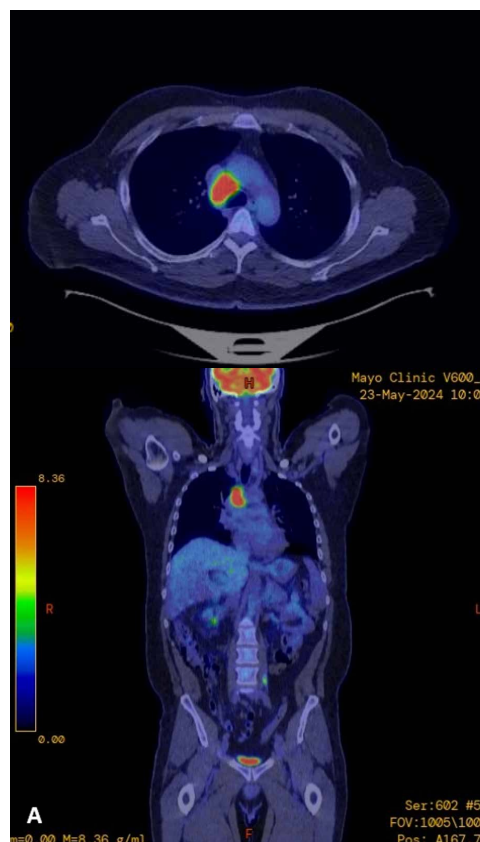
FDG-PET/CT comparison before antifungal treatment for coccidioidal lymphadenitis. Baseline FDG-PET/CT demonstrating intensely FDG-avid right paratracheal and precarinal lymphadenopathy (SUVmax 15.5), initially interpreted as malignant-appearing thoracic lymphadenopathy in the setting of newly diagnosed T1a gastroesophageal junction adenocarcinoma.
